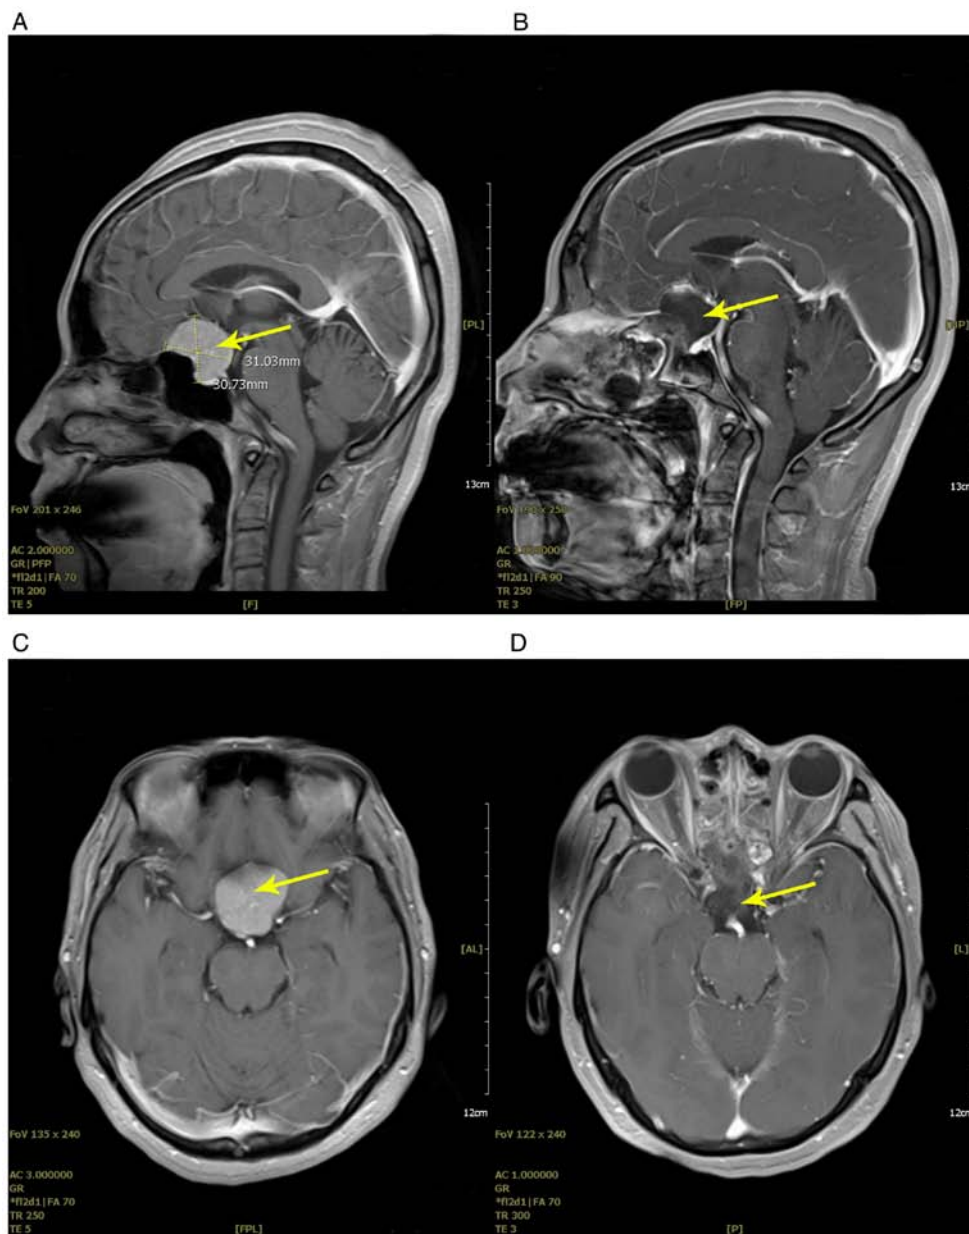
Case 1 of endoscopic transsphenoidal approach. Patient 1 was a 45-year-old female with decreased vision. (A) Sagittal image of the preoperative MRI, showing an intrasellar tumorous lesion with a maximum diameter of 31.03-mm. (B) Sagittal image of the postoperative MRI, showing no remnant tumor tissue. (C) Axial image of the preoperative MRI. (D) Axial image of the postoperative MRI. The yellow arrow indicates the tumor or the tumor cavity.
